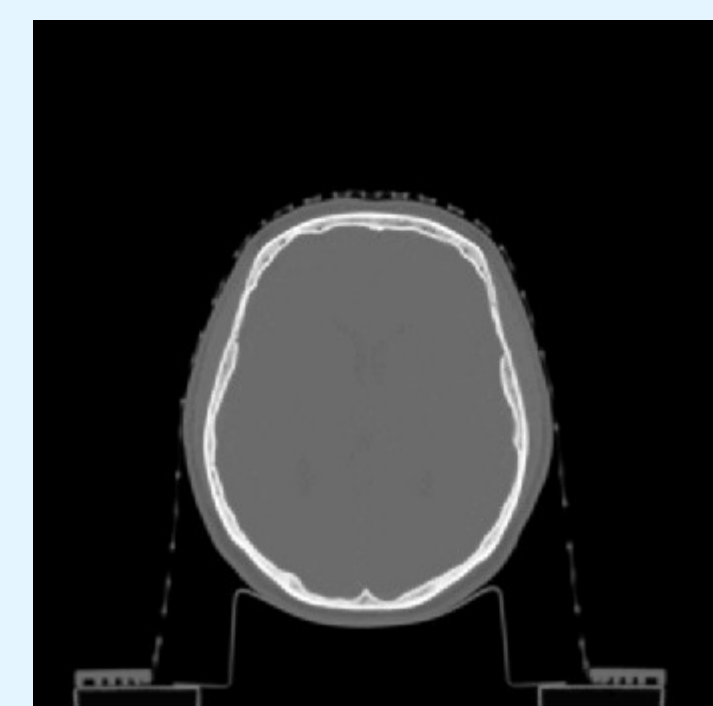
CT image, transaxial slice of human head
